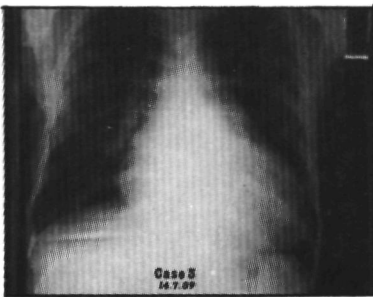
(Case 3). Chest X-rays at the time of admission (left), and after the patient's recovery ten days later (right).
